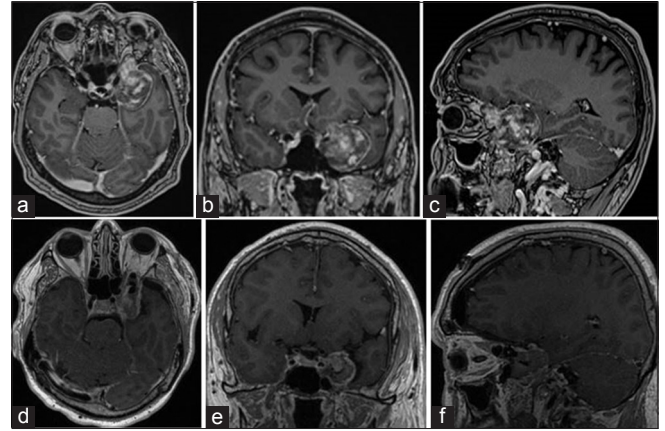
Preoperative (a-c) and postoperative (d-f) magnetic resonance imaging showing the location and gross total resection of tumor.
